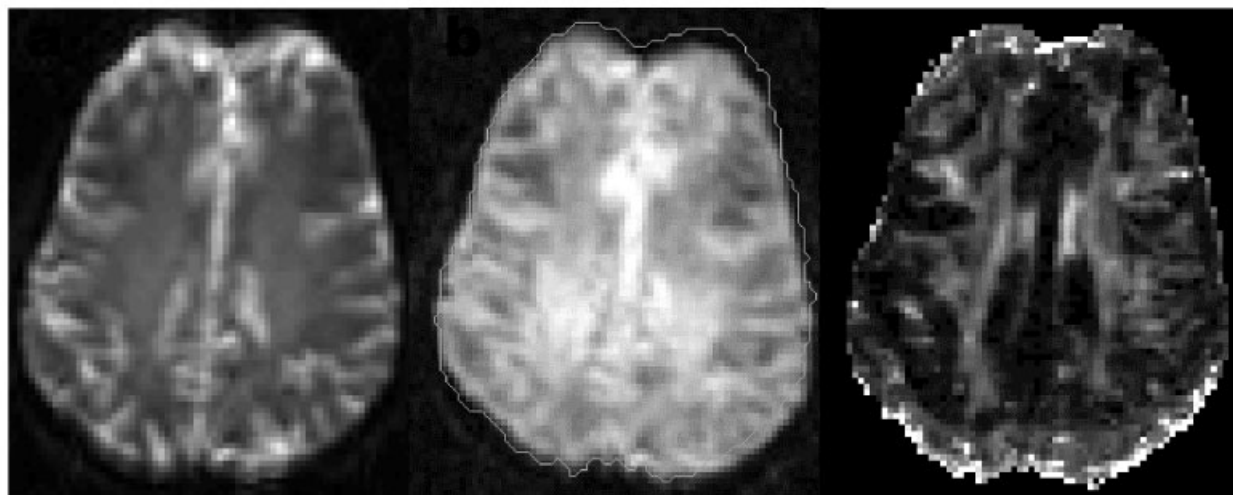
Eddy current artifacts in DT-MRI (the phase encode direction is anterior–posterior). (a) Non-diffusion-weighted image. (b) Diffusion-weighted image (intensity increased to identify slice boundaries). The contour of the non-diffusion-weighted image in (a) is shown as an overlay. (c) Fractional anisotropy image computed from the data set. Note the presence of a ‘rim’ of high anisotropy in the phase-encode direction
